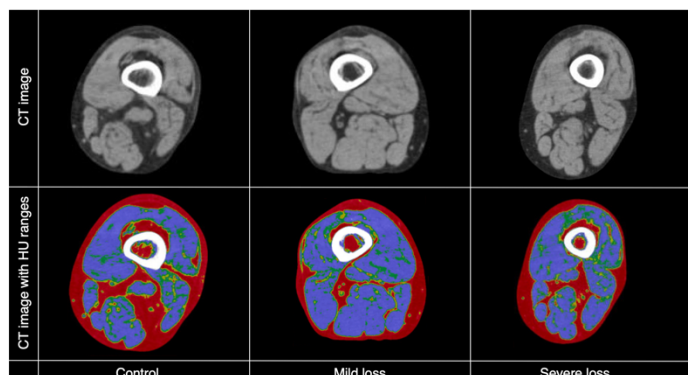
Figure CT images with HU ranges at 15% proximal to the patellar. Red: -190 to -30HU, Yellow: -29 to -1HU, Green: 0 to 34HU, Blue: 35 to 100HU, White: 101-1000HU.
